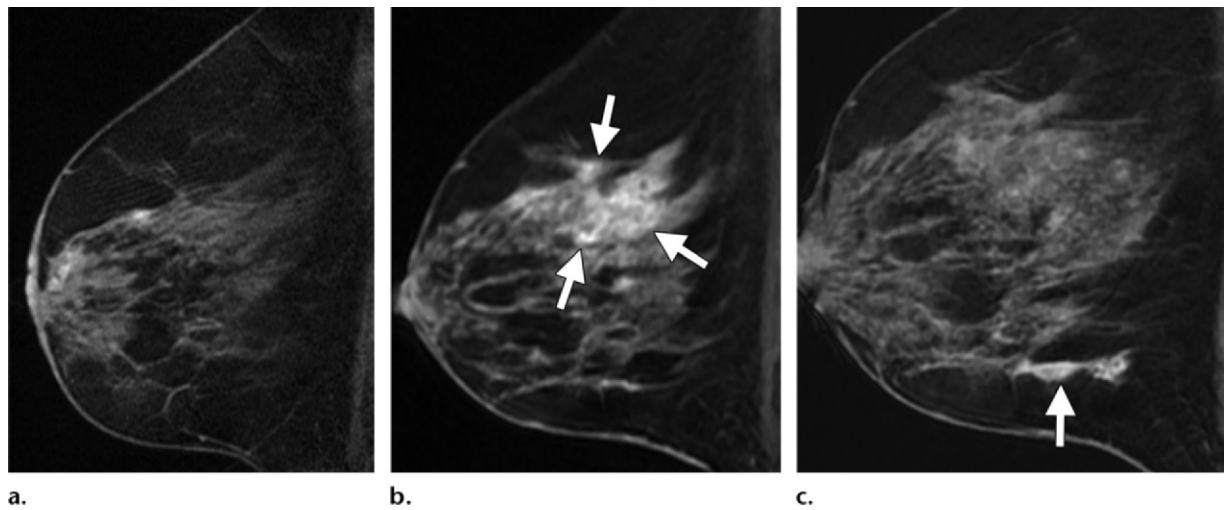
Effect of tamoxifen treatment on BPE in a 46-year-old high-risk woman with previous contralateral breast cancer that was treated with breast conservation therapy and tamoxifen. (a) Sagittal contrast-enhanced T1-weighted fat-suppressed MR image obtained during tamoxifen treatment in 2009 shows minimal BPE. (b) Sagittal contrast-enhanced T1-weighted fat-suppressed MR image obtained in 2010 after completion of tamoxifen treatment shows increased moderate BPE (arrows). (c) Sagittal contrast-enhanced T1-weighted fat-suppressed MR image obtained in 2011 shows mild BPE (arrow) in the inferior portion of the breast with rapid persistent kinetic features, a finding that was interpreted as a focal area of NME. An MR imaging–guided core-needle biopsy demonstrated normal breast tissue with gynecomastoid change. The finding resolved at follow-up MR imaging (not shown). Tamoxifen rebound may manifest as global or diffuse enhancement or focal areas of BPE.
